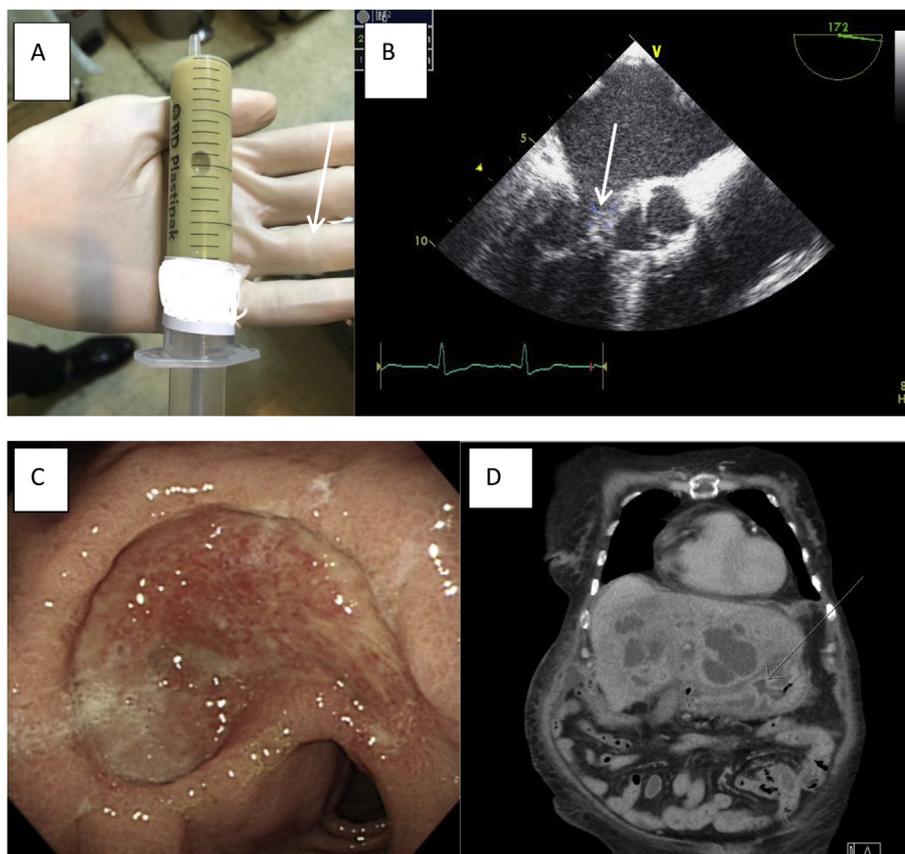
(A) Showed about 200 ml pus-like fluid by echo-guided aspiration from the liver abscess. (B) Transesophageal echocardiography showed one vegetation (0.65×0.89 cm) over anterior mitral valve leaflet with moderate mitral regurgitation (white arrow). (C) A big active ulcer about 7×5 cm at the antrum of the stomach. (D) Contrast-enhanced computed tomography images of the abdomen and pelvis showed multi-loculated hepatic lesions and a tumorous like lesion at the antral part of the stomach (scale bar).
